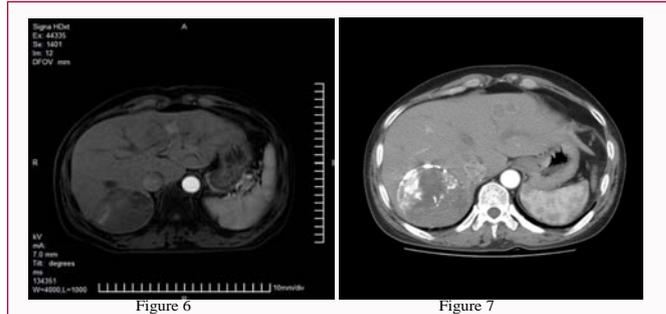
The enhanced CT reexamination on August 17, 2015 showed that the maximum diameter of the tumor was 8.13 cm × 7.80 cm, which was stable compared with the previous image (Figure 6). However, by December 30, 2015, the tumor had slowly progressed to 10.0 cm × 8.6 cm (Figure 7).
